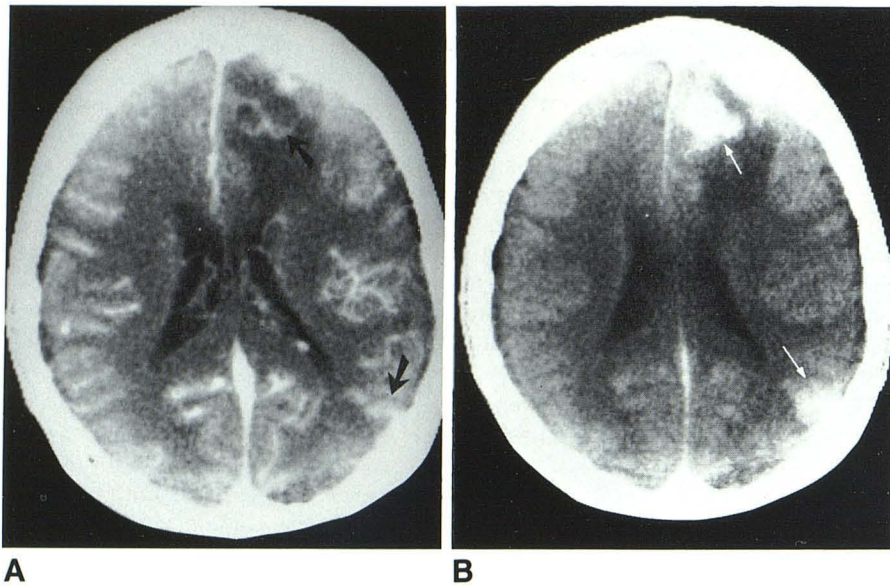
Homosexual with *Toxoplasma* encephalitis. A, High-resolution IDD CT scan. Two areas of abnormal enhancement (*arrows*). B, DDD scan. With time delay, more contrast material accumulated in these two lesions, making them denser and larger (*arrows*). Two other sites of involvement were identified in left temporal lobe on DDD study (not shown).
